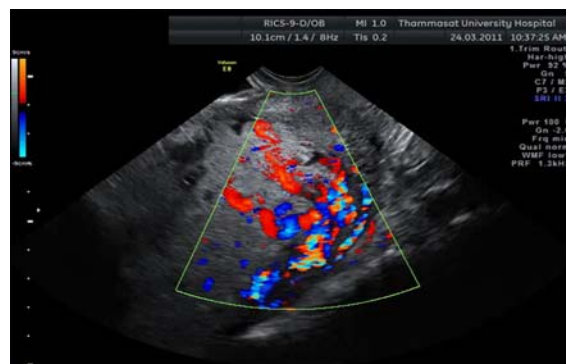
Trans-vaginal Color Doppler imaging showing abnormal vasculature between placenta and posterior myometrium.
